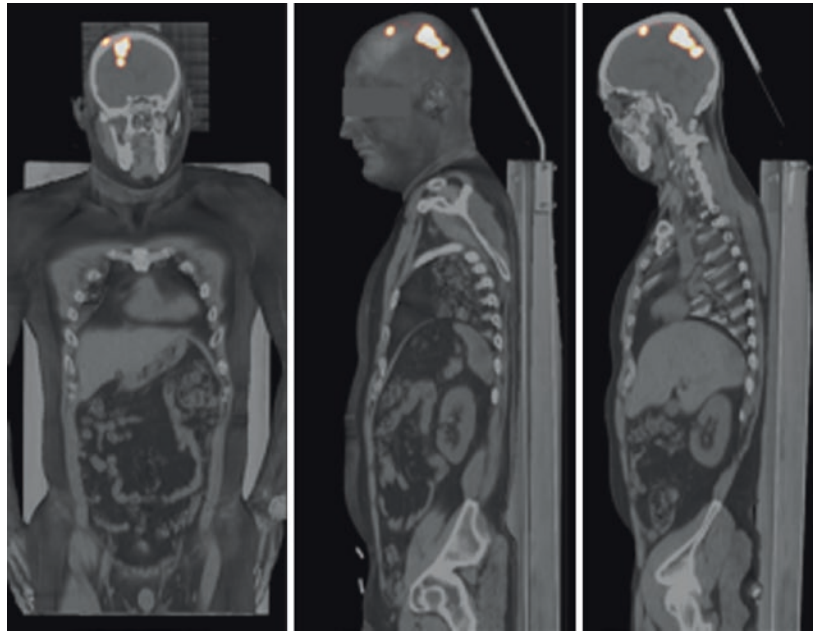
Problems with catheter. ^{68}Ga -DOTA-SP PET/CT after intracavitary injection of 10 MBq ^{68}Ga -DOTA-SP. The picture shows obstruction of catheter
